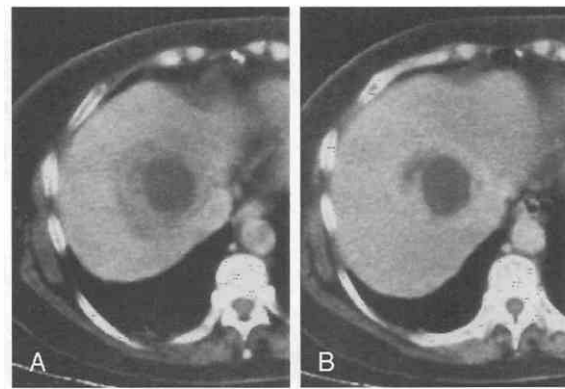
Pyogenic abscess. *A*, Unenhanced CT scan shows a zone of intermediate densities that surrounds the central low-attenuation cavity. *B*, Contrast-enhanced CT scan reveals the hyperemic peripheral zone to enhance.
